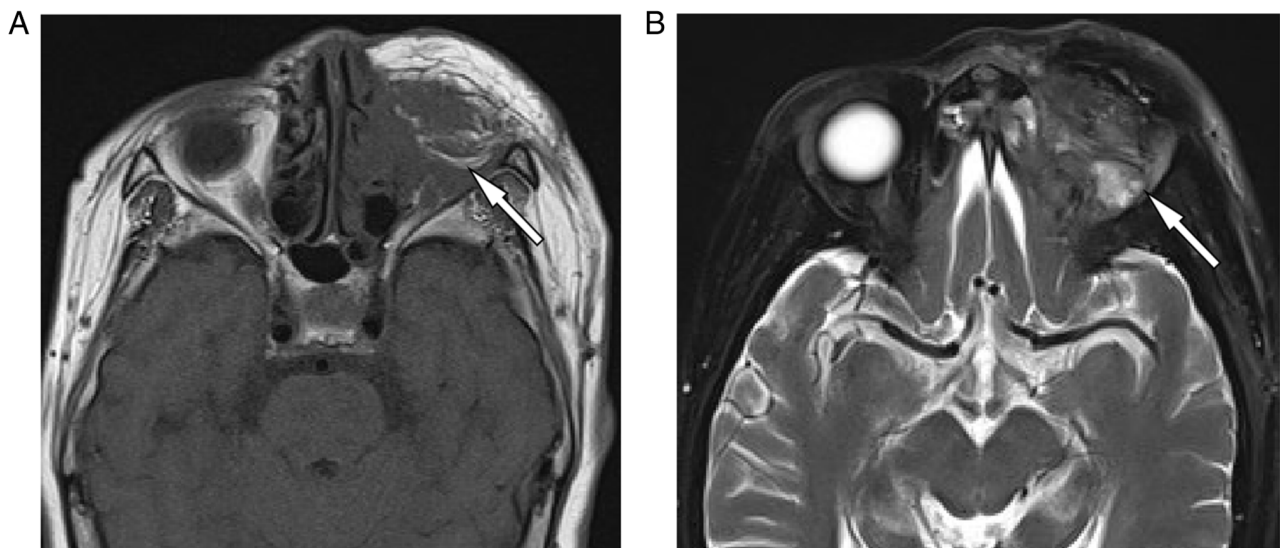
Magnetic resonance imaging at 7 months and 1 week after surgery, which showed a postoperative absence of the left eyeball, and a heterogeneous lump presenting with (A) a slightly hypointense signal on T1WI and (B) a slightly hyperintense signal on T2WI in the operative area, suggesting tumor recurrence. WI, weighted imaging.
